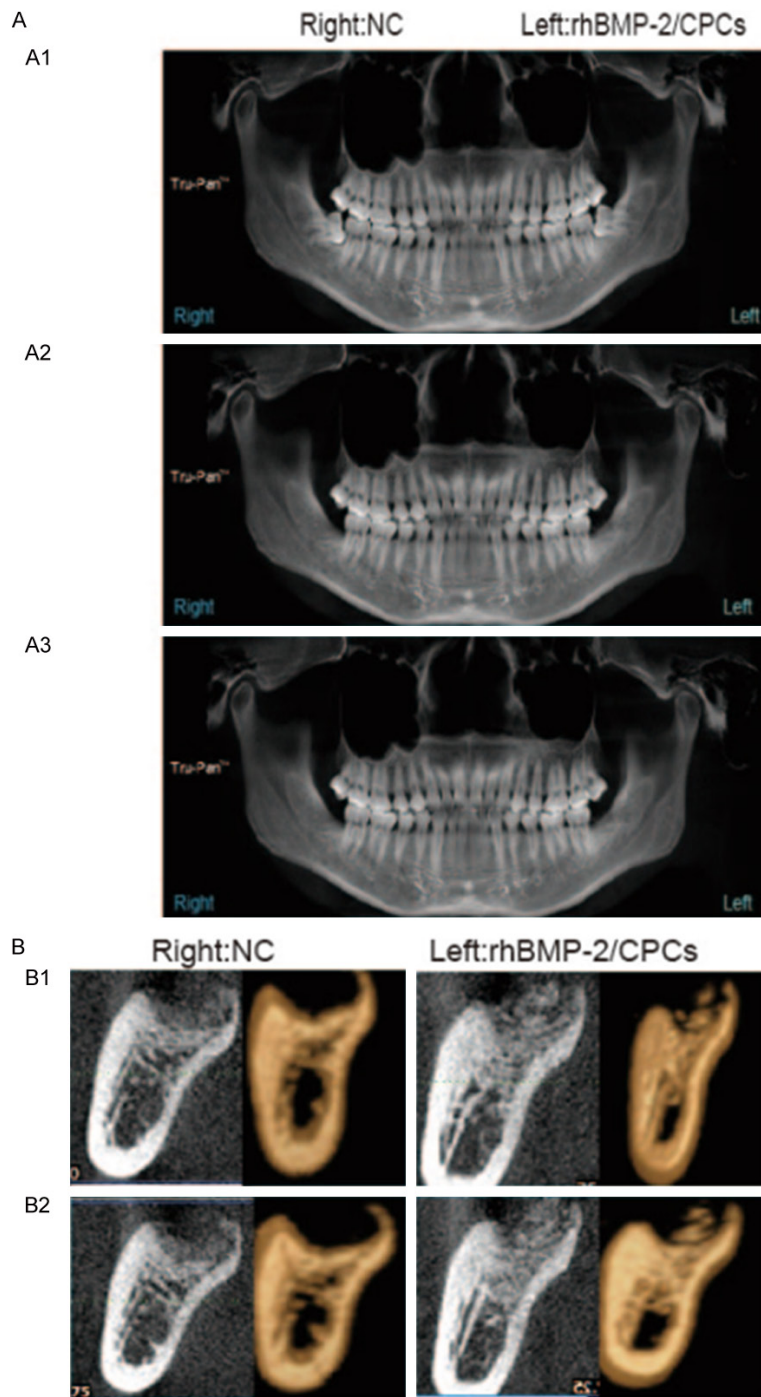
CBCT image analysis of CPCII implantation in the extraction socket after the extraction of IMM3. A: Panoramic radiograph. B: The coronal image and 3D reconstruction views of the CBCT image. A1: Before the extraction of IMM3. A2, B1: Three months post-extraction with/without CPCII implantation. A3, B2: Twelve months post-extraction with/without CPCII implantation. Right: negative control (NC); Left: extraction socket post-extraction with CPCII.
